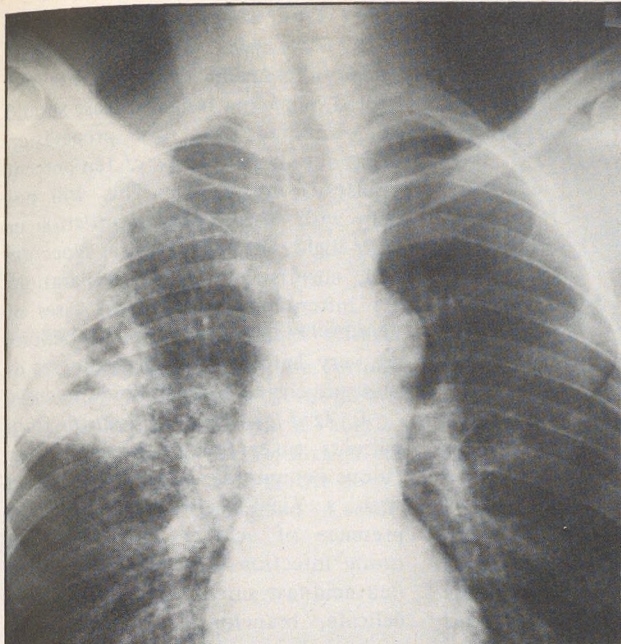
Chest radiograph of a post-operative patient with necrotizing pneumonia of the right upper lobe secondary to *Pseudomonas*. The patient was on intermittent positive pressure breathing (IPPB) therapy.
